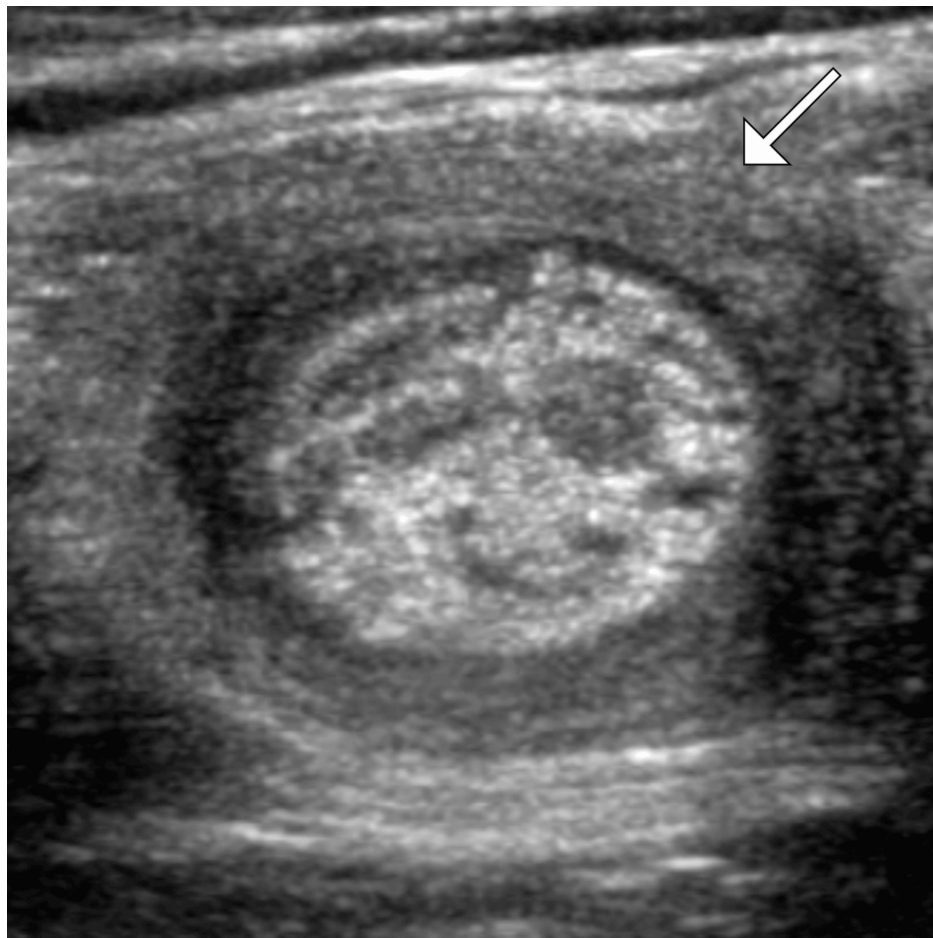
Grey-scale ultrasound image showing the classic "target sign" (arrow) of intussusception
